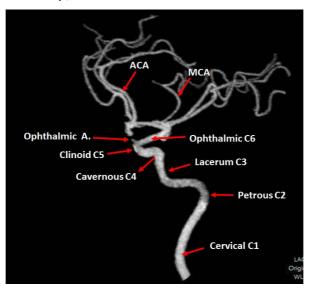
CTA, 3DVR of right ICA, lateral view, branching into MCA (the more horizontal branching) & ACA (the more vertical branching). (Image from Radiology department, Ain Shams University)
